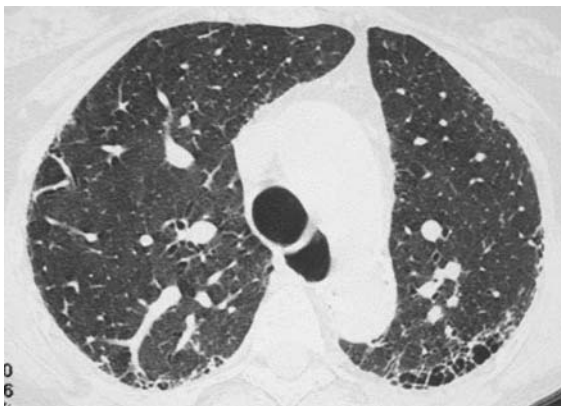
A 64-year-old woman with scleroderma. HRCT scan through the lung bases shows typical features of interstitial lung fibrosis. Note the dilatation of the upper esophagus.
